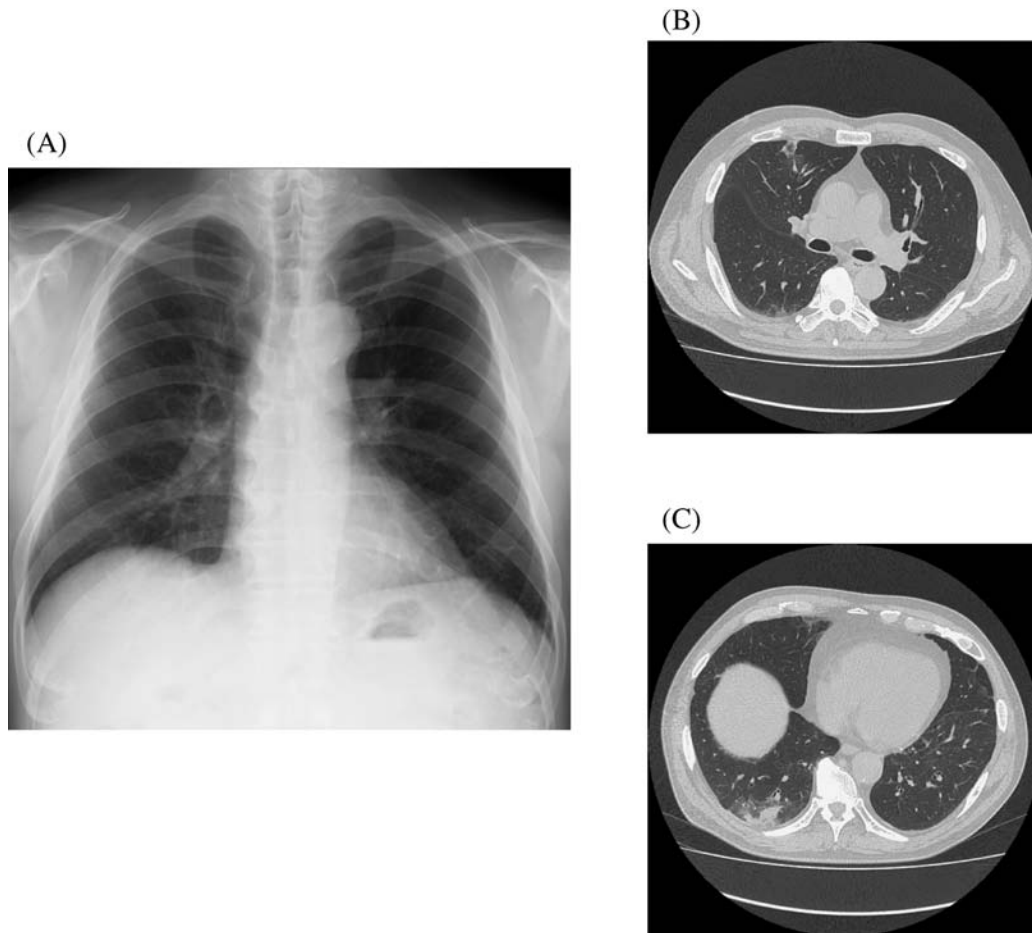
Chest X-ray films before albendazole treatment (17 days after admission). (A) Chest X-ray film showing infiltrative shadow in right middle and lower lung fields and migrated from the time of admission. (B) and (C) CT scan images showing new consolidation with ground-glass opacity at right upper and lower lobes.
